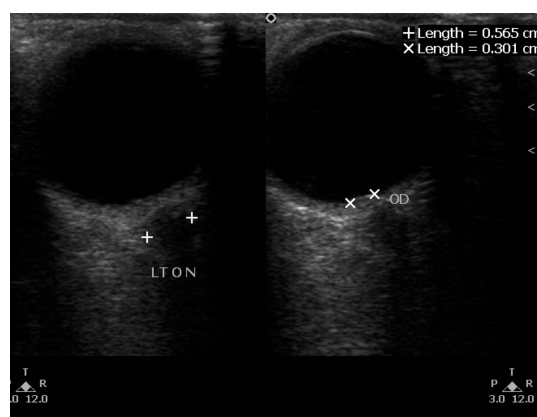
Ophthalmic B-scan ultrasound showing increased optic nerve diameter >5 mm OU suggestive of Papilledema.
